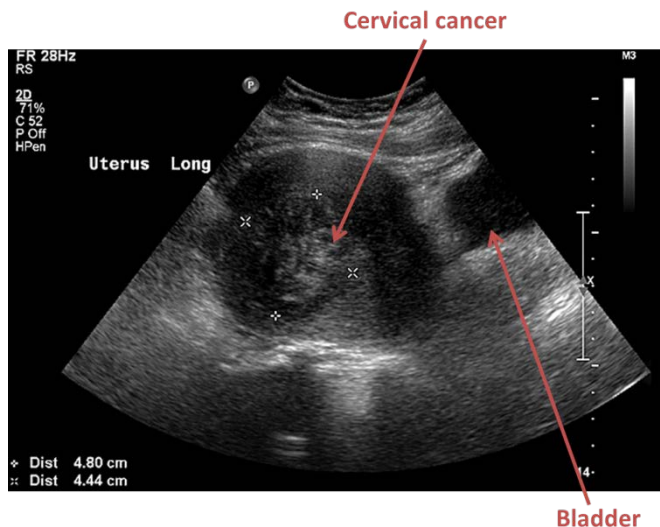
Pelvic ultrasound. University of Massachusetts Medical School, Department of Radiology.
